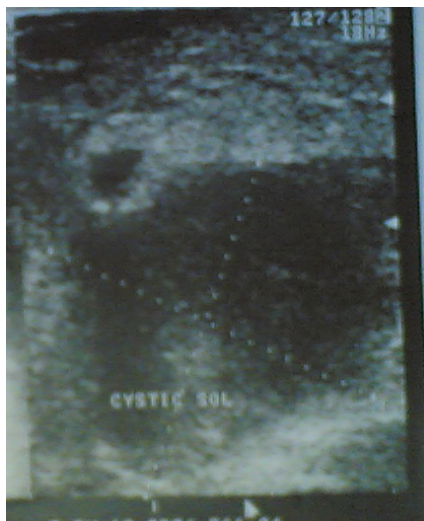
Ultrasonography of breast showed hypoechoic lesion with multiple internal echoes
